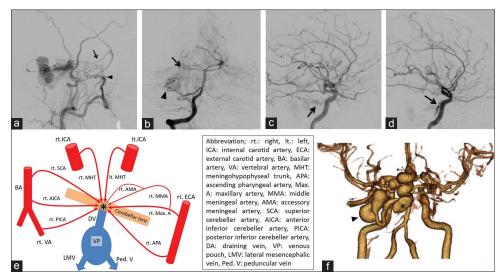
(a) Lateral view on a right external carotid angiogram. The MMA (arrow) and Max. A (arrowhead) are feeding the TDAVF. (b) Anteroposterior view on a right vertebral angiogram. The SCA (arrow) and AICA (arrowhead) are feeding the TDAVF. Lateral view on carotid angiogram (c:right, d:left) showing dilated tentorial arteries (arrows). (e) Simplified scheme relationship among feeing arteries (red), draining veins (blue) and shunting point (asterisk). (f) 3D-CTA after endovascular treatment. The venous pouches of the midbrain became smaller (asterisk). The venous pouch of the CP angle did not change (arrowhead)
